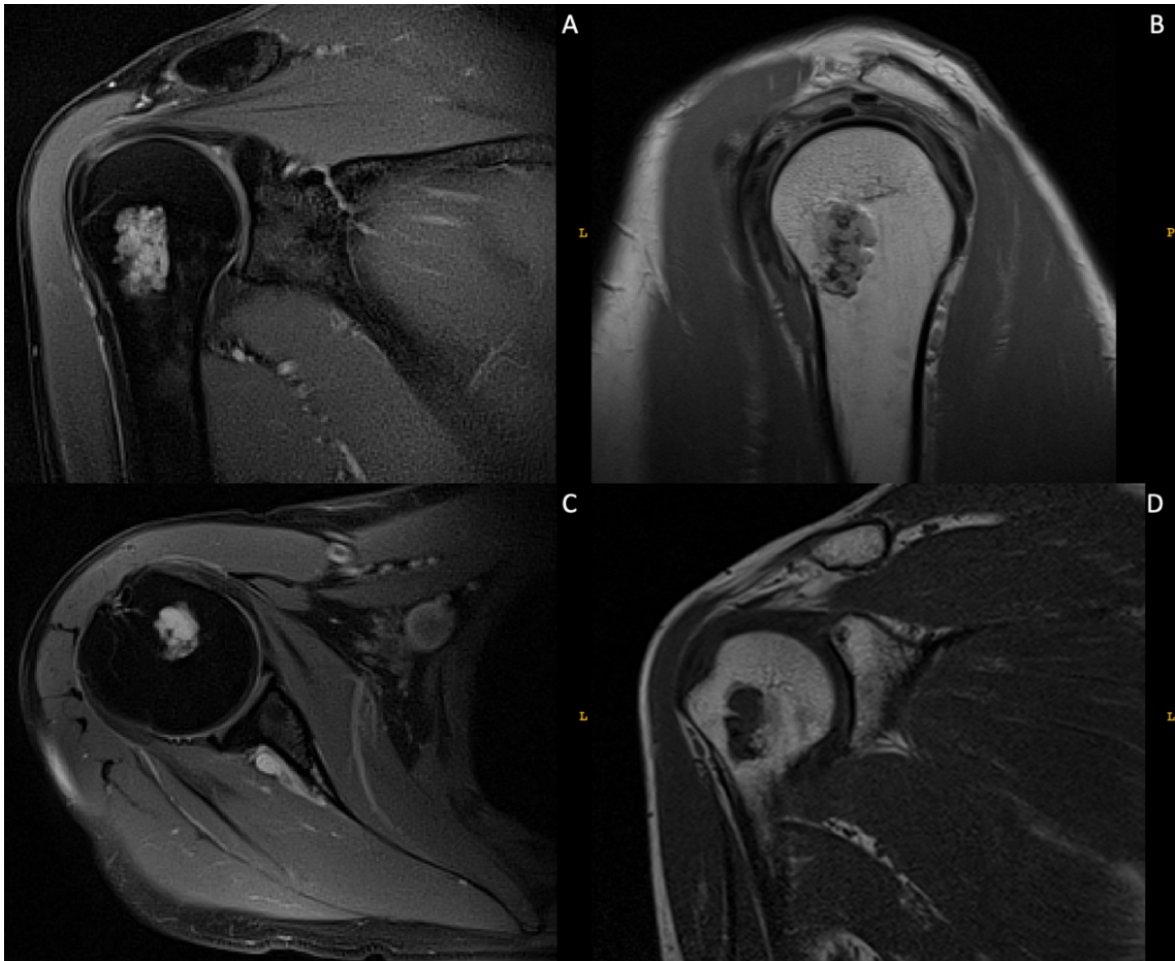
MRI scan of an enchondroma of the right humerus (male, 59 years): (A) proton density, blade with fat suppression, coronal; (B) proton density + t2, sagittal; (C) proton density, blade with fat suppression, transversal; (D) t1, coronal, spin echo.
